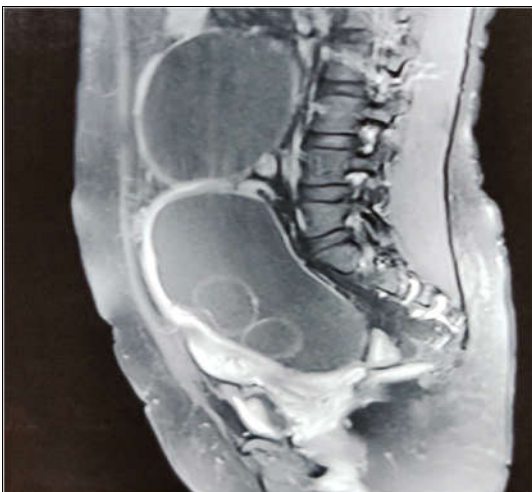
MRI showing thin walled ovarian cysts in both ovaries
